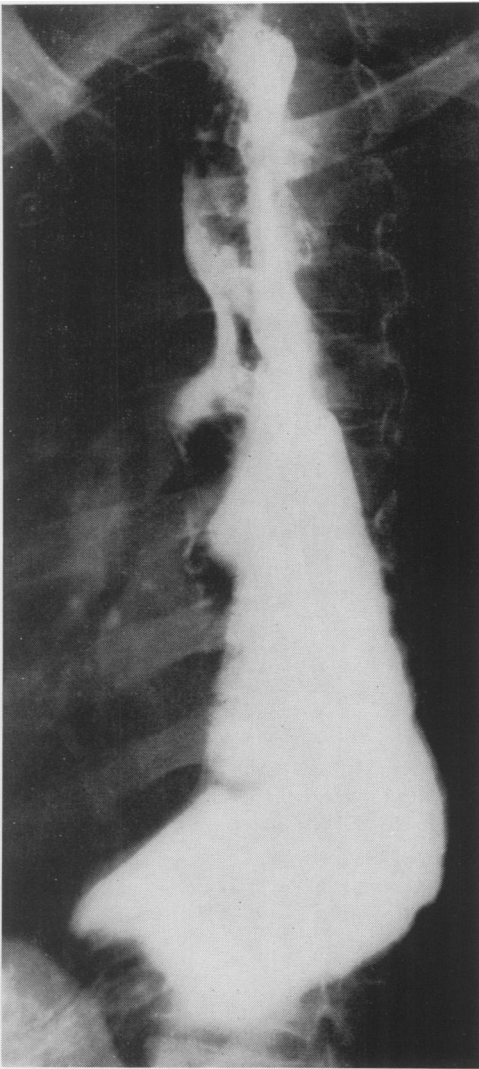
Flask-shaped deformity in roentgen picture in a case of achalasia of the esophagus.
